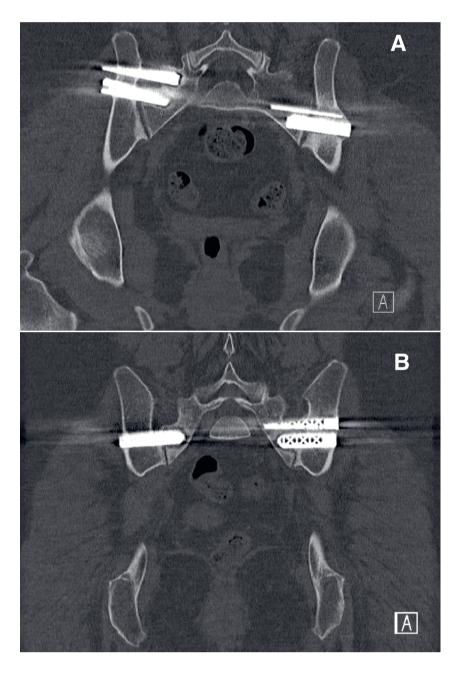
Two cases of implant loosening on pelvic CT scan. In both cases radiolucency around the implants on the right can be detected without any intra-articular bridging of trabeculae over the SIJ.
